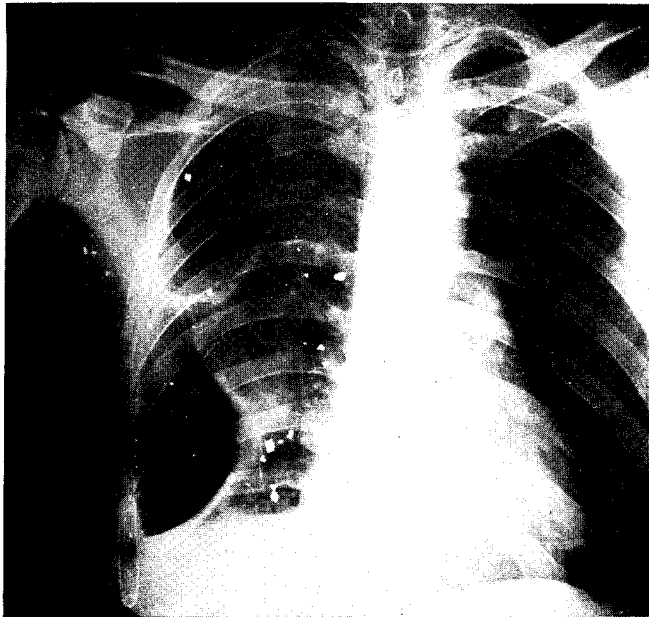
Roentgenogram of thoracic cavity of soldier who was prone on the ground when a mortar shell of unknown size exploded 1-yard distant. This soldier was also wounded in the arm, thigh, and both ankles. An open operation was performed, and the numerous lacerations in the lung, caused by the small fragments, were sutured and the intercostal vessels ligated. The soldier made a good recovery.
